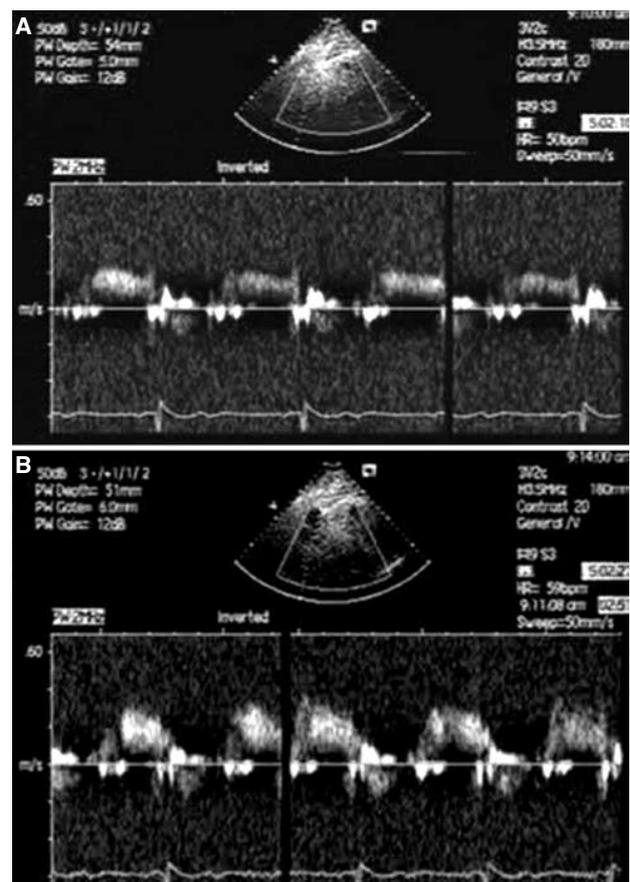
Demonstration of coronary flow velocity at (A) baseline and (B) hyperemia obtained by transthoracic pulsed wave Doppler echocardiography in the distal left anterior descending coronary artery.
